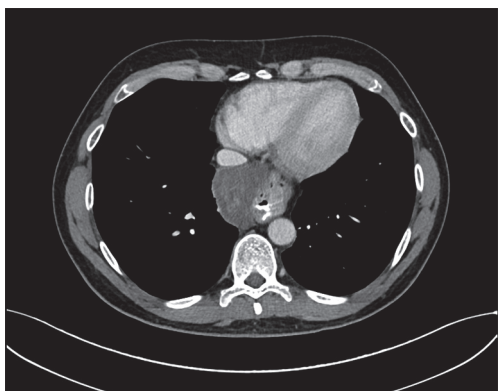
Contrast-enhanced computed tomography after 9 months of imatinib therapy showing a reduction of the tumor mass of 83%.
